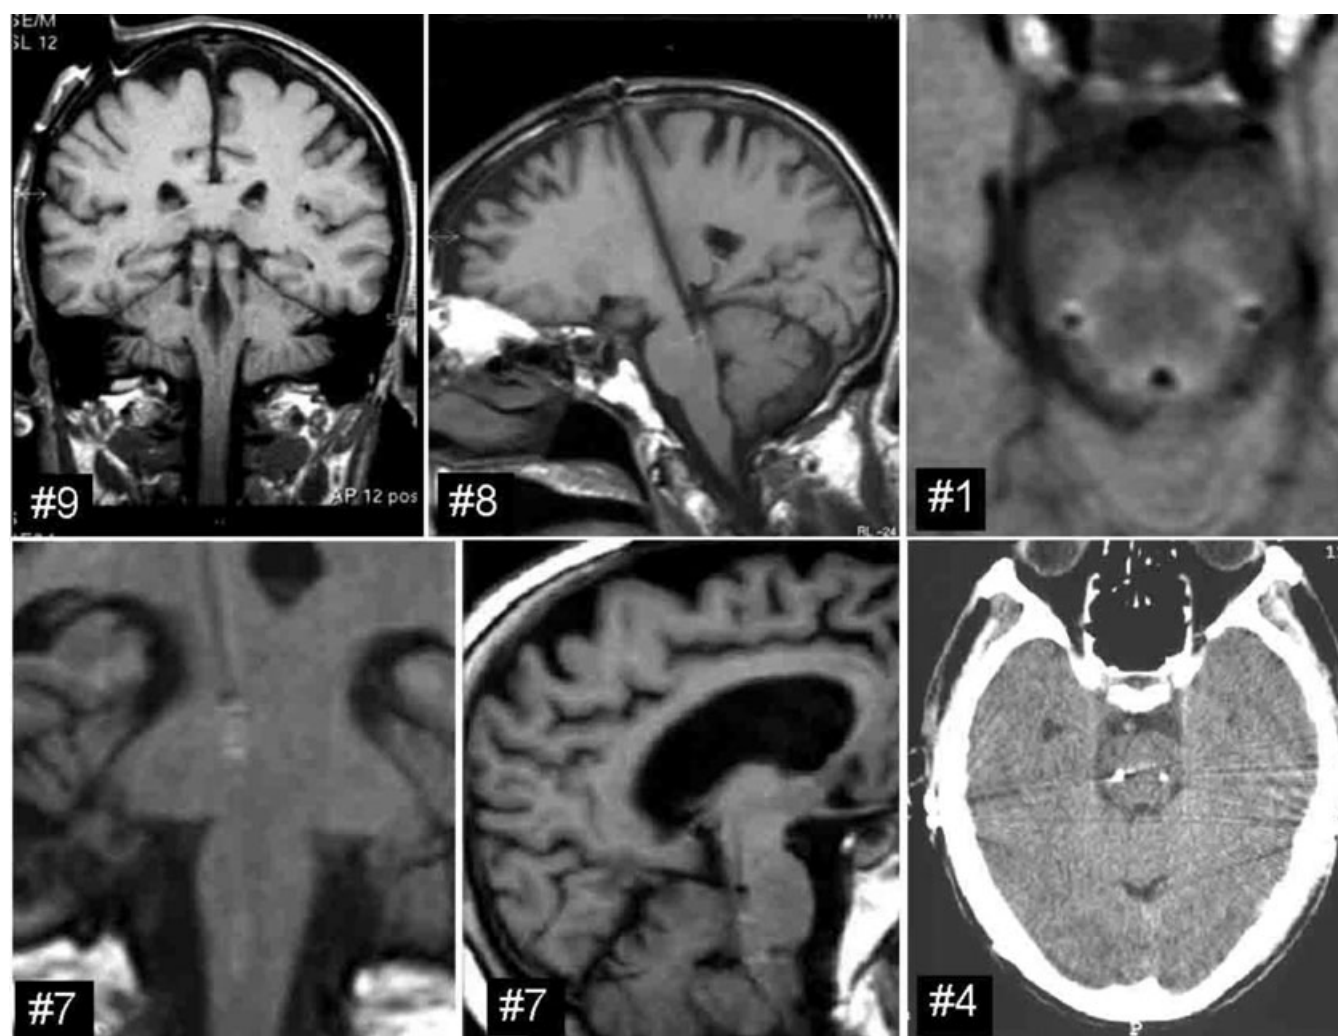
Postoperative magnetic resonance imaging control scans from patients #1, #7, #8, and #9 and postoperative CT control scan from patient #4 (lower right panel).
